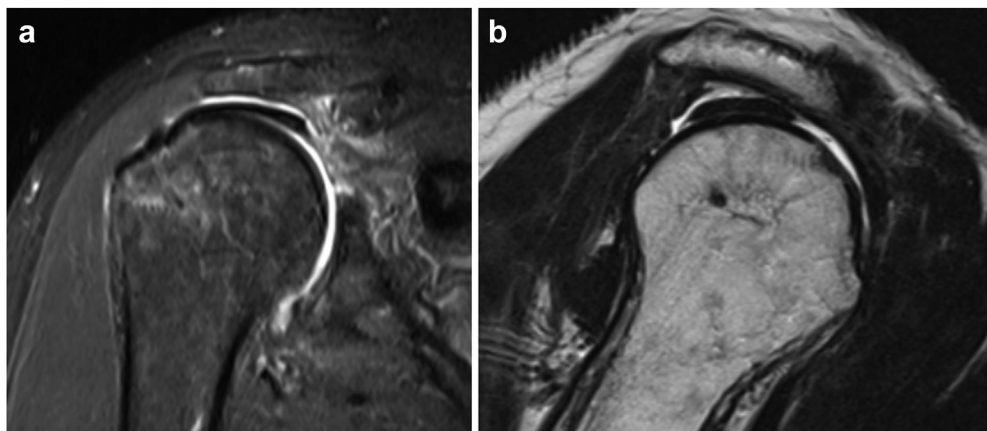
(a) Postoperative coronal T2 and (b) sagittal T1 MRI at one year showing intact graft. MRI, magnetic resonance imaging.
